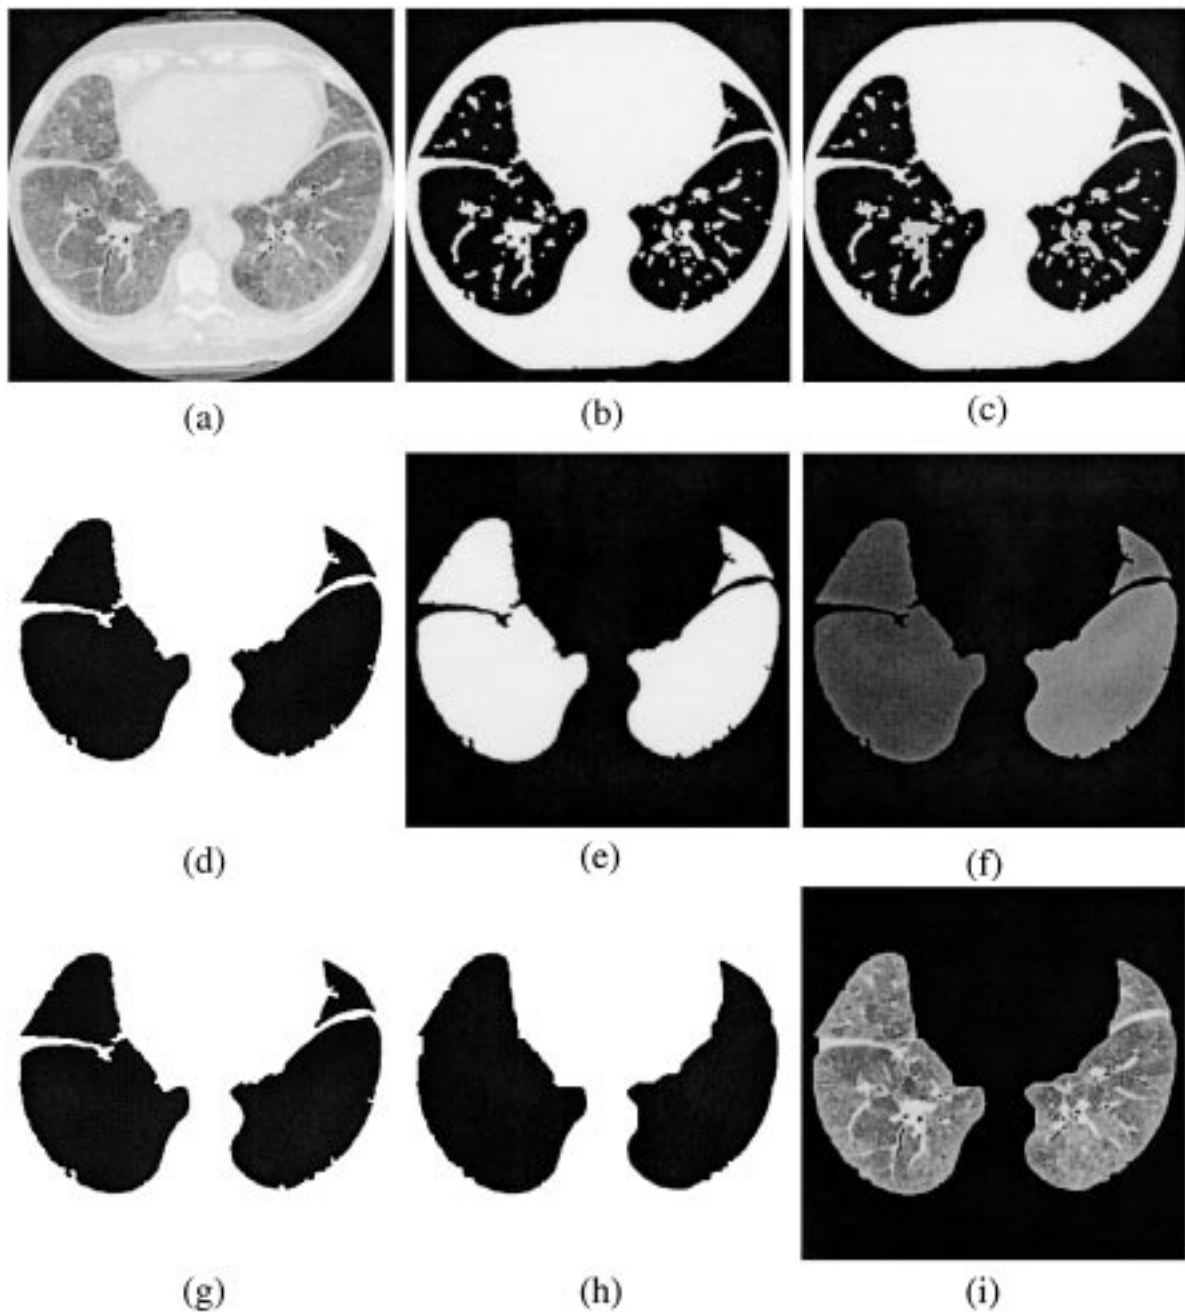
The intermediate results from lung region extraction algorithm: (a) an HRCT image, (b) after thresholding to separate out high-attenuation pixels, (c) after component labeling, (d) after applying the ratio test, (e) complement of image in (d), (f) component labeling of the complement image, (g) after applying the ratio test to the complement image, (h) after the application of dilation and erosion operators (h) the final result which has only the lung regions.
